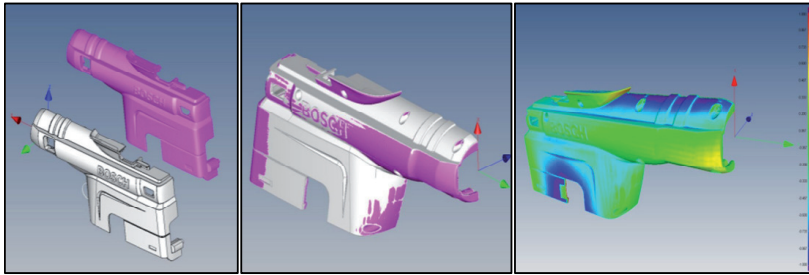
CAD model (left) with CT data and evaluation of geometry deviations with default toleration field (middle and right).
